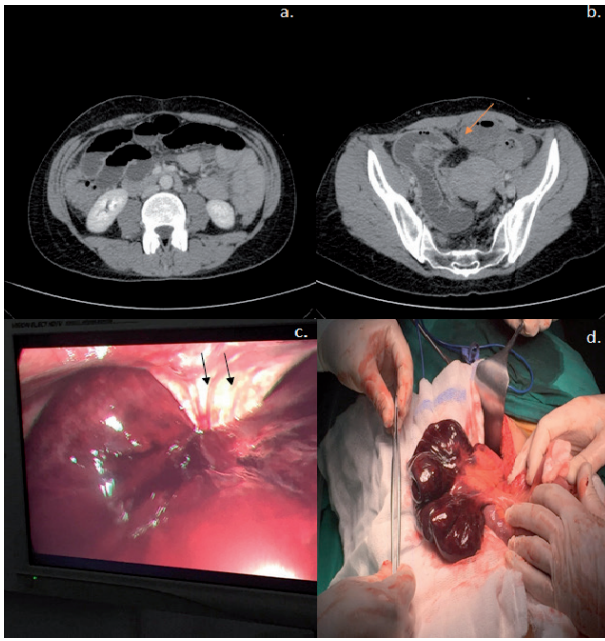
a. Multi-slice contrast-enhanced CT of the abdomen and pelvis (18 hours from admission) showing dilated small bowel with air-fluid levels and surrounding mild amount of fluid. b. The afferent and efferent loops showing positive beak sign (red arrow) suggesting adhesive band. c. Laparoscopic view showing a strangulated closed-loop obstruction involving the terminal ileum. The herniated segment was found to be strangulated within an anterior abdominal wall adhesive band causing a small window (black arrows) close to the site of previous Pfannenstiel incision scar. d. Laparotomy view of a 20 cm strangulated loop of distal ileum which was not viable and had to be resected.
